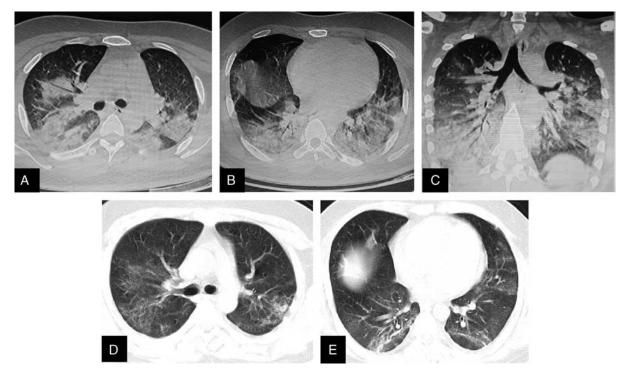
CT of the chest in axial (A, B) and coronal (C) images obtained on the eighth day of the disease course showed ground-glass opacities and consolidations in bilateral lungs, more prominent in both the lower lobes, right upper lobe, right middle lobe, and the apicoposterior segment of the left upper lobe. CT of the chest (D, E) obtained on the 19th day of the disease course showed bilateral pulmonary ground-glass opacities and patchy consolidations that were significantly regressed in comparison with the last CT images (A–C) obtained 11 days ago.
